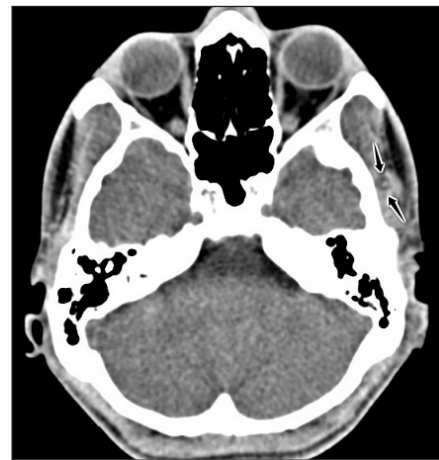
Axial CT in a 21-year-old patient at the level of temporalis muscle showing a cyst with mural nodule in the left temporalis muscle (arrow)
